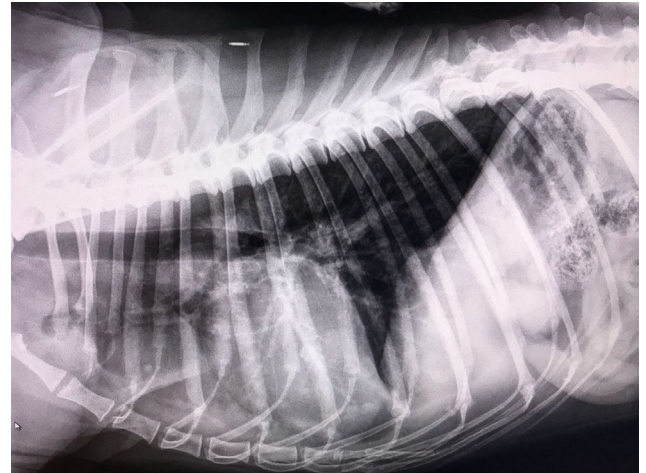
Right lateral thoracic radiograph showing a oval shaped area of increased opacity cranial to the cardiac outline consistent with a mass and a number of areas of patchy increase in opacity overlying the lung fields
